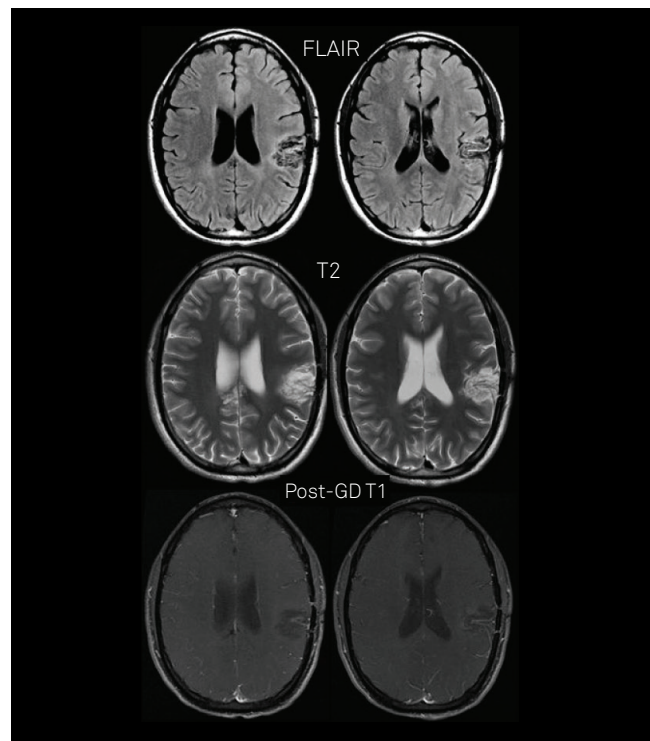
One-year follow-up magnetic resonance imaging. The patient was asymptomatic. Sequelar lesions were detected, without enhancement or mass effect.
